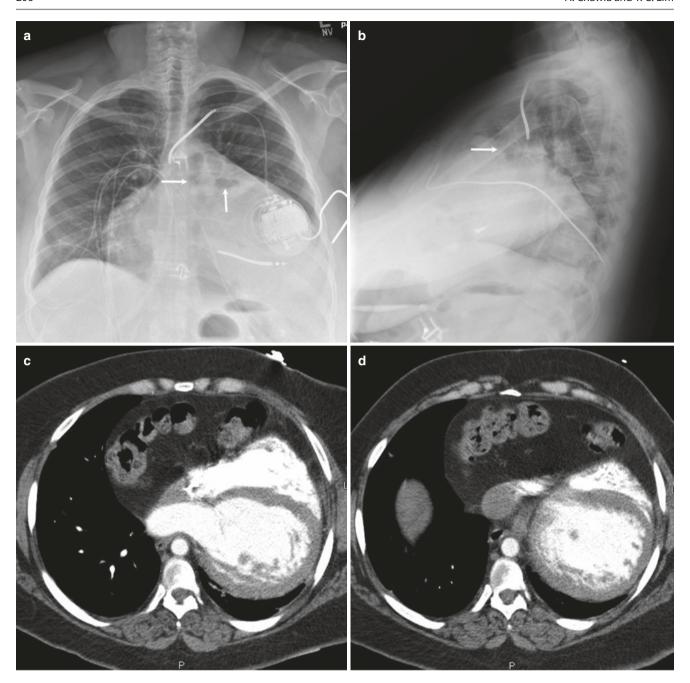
64-year-old woman with Morgagni hernia containing transverse colon. (a, b) Frontal and lateral radiographs show large central mediastinal mass with bowels and air-fluid level (arrows). (c, d) Axial CT images reveal herniated transverse colon and fat displacing the heart
